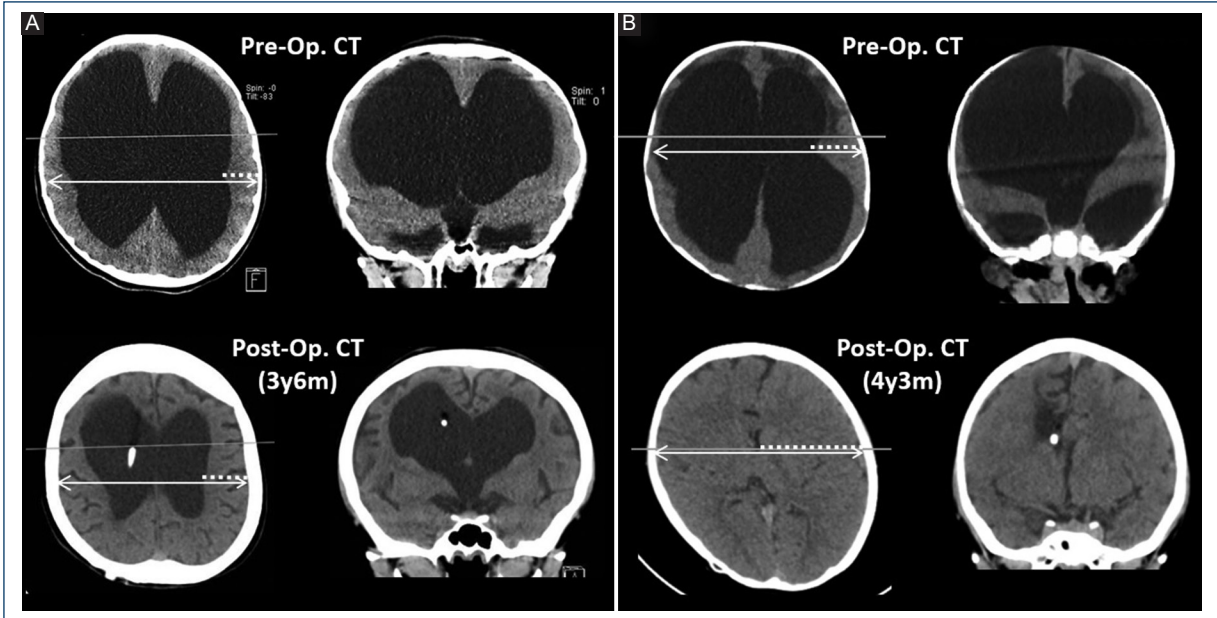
Computed tomography (CT) scans of two cases of extreme hydrocephalus treated with ventriculoperitoneal shunting. A: case 2, female, 10 years 9 months of age at the time of diagnosis (upper images) and 3 years 6 months after shunt placement (lower images). B: case 4, male, 6 months of age at the time of diagnosis (upper images) and 4 years 3 months after shunting. The horizontal continuous lines represent the level of CT sections; the dashed white lines on the axial images indicate the region where cerebral parenchymal thickness was measured, and the double-head arrow lines show how the intracranial diameter was measured at the same level.
